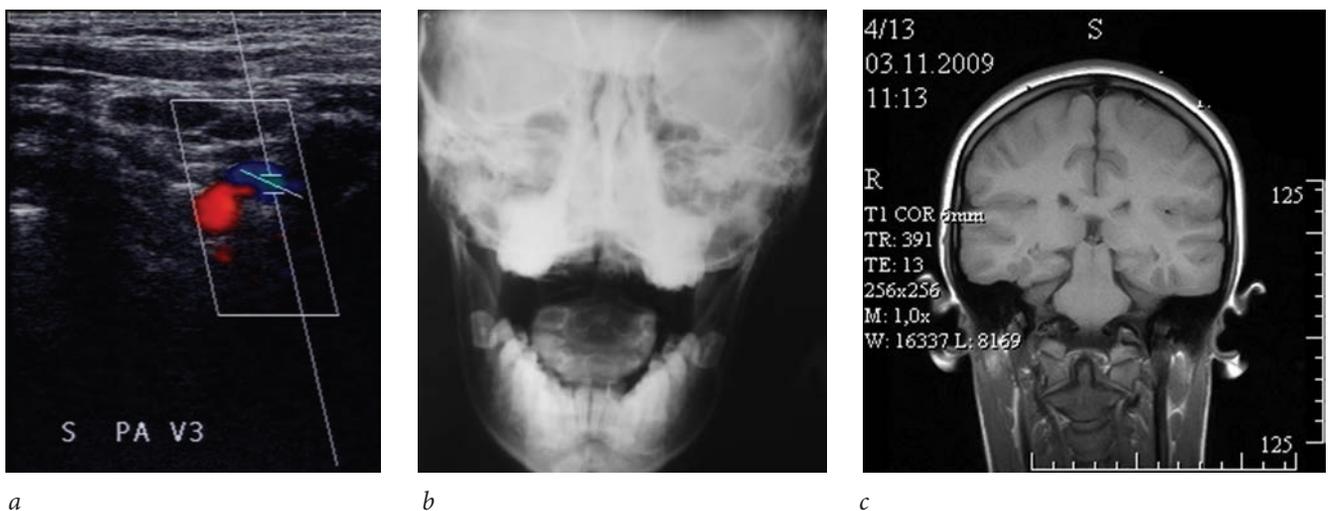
Patient B., 12 years old. Ultrasonogram of the acquired kinking deformity of the V_3 segment of vertebral artery (a); X-ray images of the cervical spine through the open mouth revealed asymmetric position of the odontoid process of C_2 relative to the lateral mass of the atlas (b); magnetic resonance tomography of the cervical spine showed MRI signs of atlas rotary subluxation (c)
